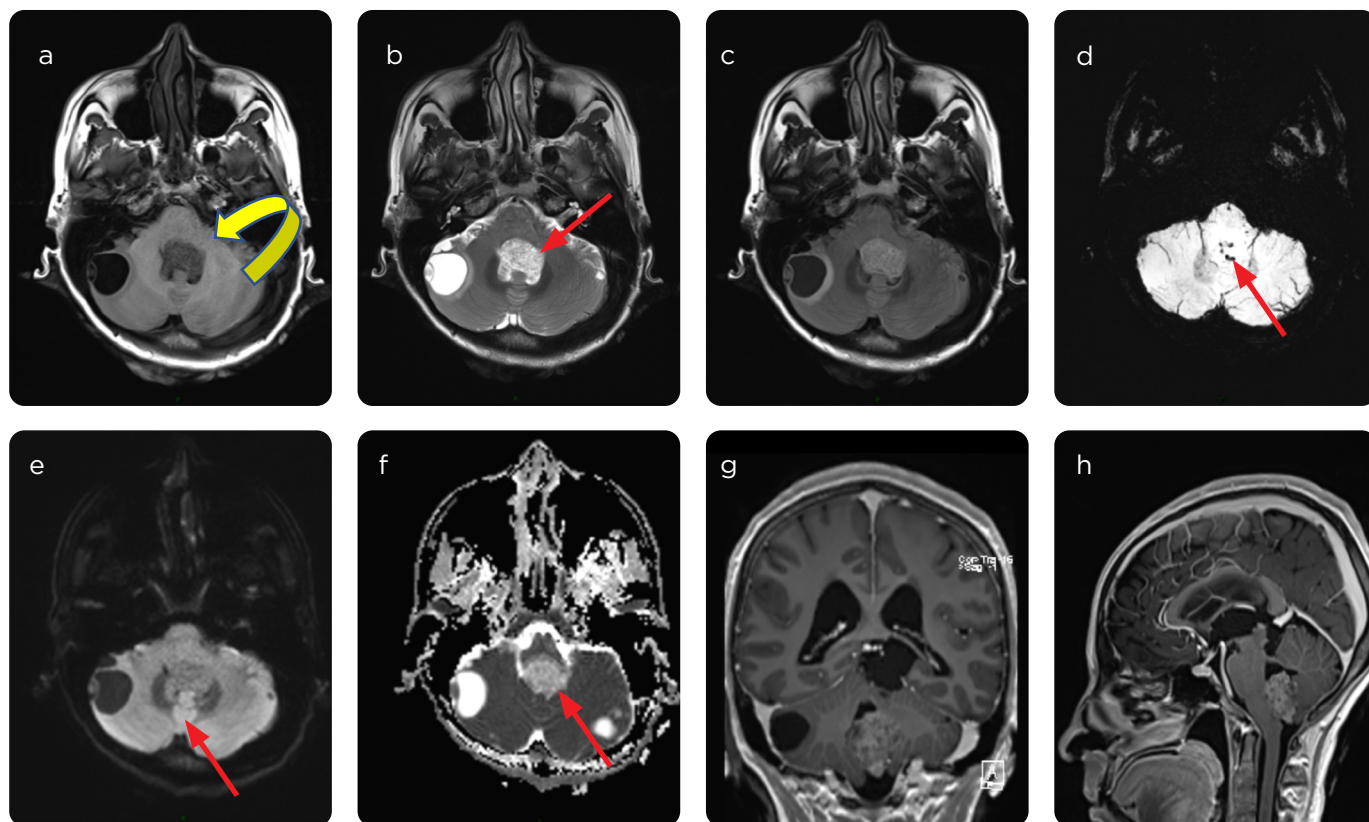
Papilloma of the IV ventricle MRI. a) Sequence with T1 information: low signal. b) Spin echo sequence; and c) FLAIR sequence with T2 information: high signal. d) Magnetic susceptibility sequence; low signal attributed to calcium. e) Diffusion sequence and f) ADC map: no restriction to water diffusion. g and h) With contrast medium: heterogeneous enhancement attributed to calcium.
